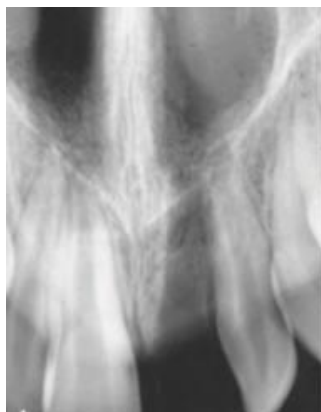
Radiograph of a patient who lost a central incisor as the result of trauma. Replantation was performed (Dean, 2021).
